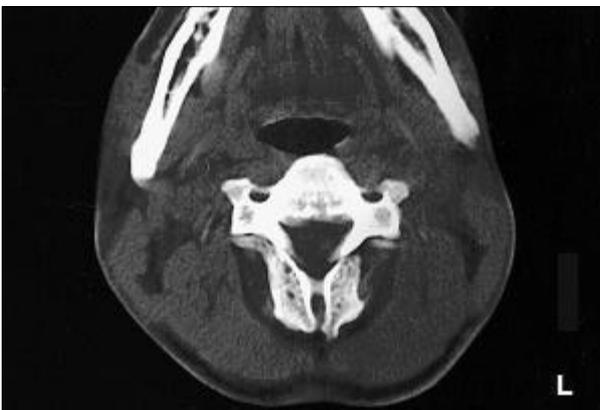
Fusion abnormality of the posterior elements of C2 vertebra is seen on bone window-CT scan.
